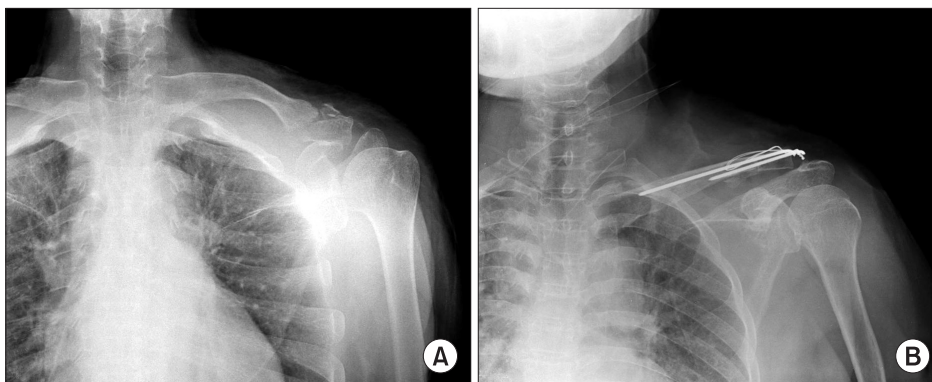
Anteroposterior radiograph of left shoulder. Preoperative (A) and postoperative (B) radiograph shows left distal clavicle fracture and internal fixation state with K-wire.
